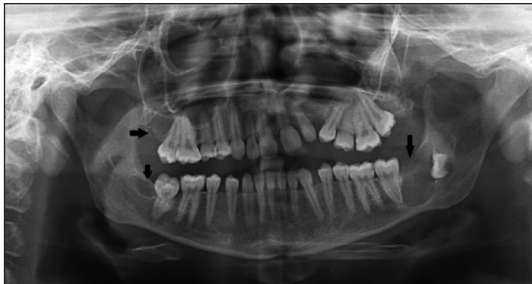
Panoramic radiography is showing unilocular, well-defined radiolucent lesions.
